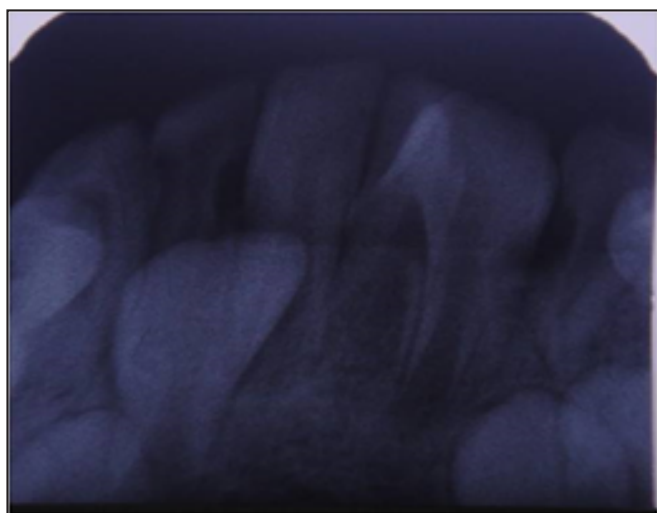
Intraoral Periapical radiograph showing fusion of crowns with two separate roots.
